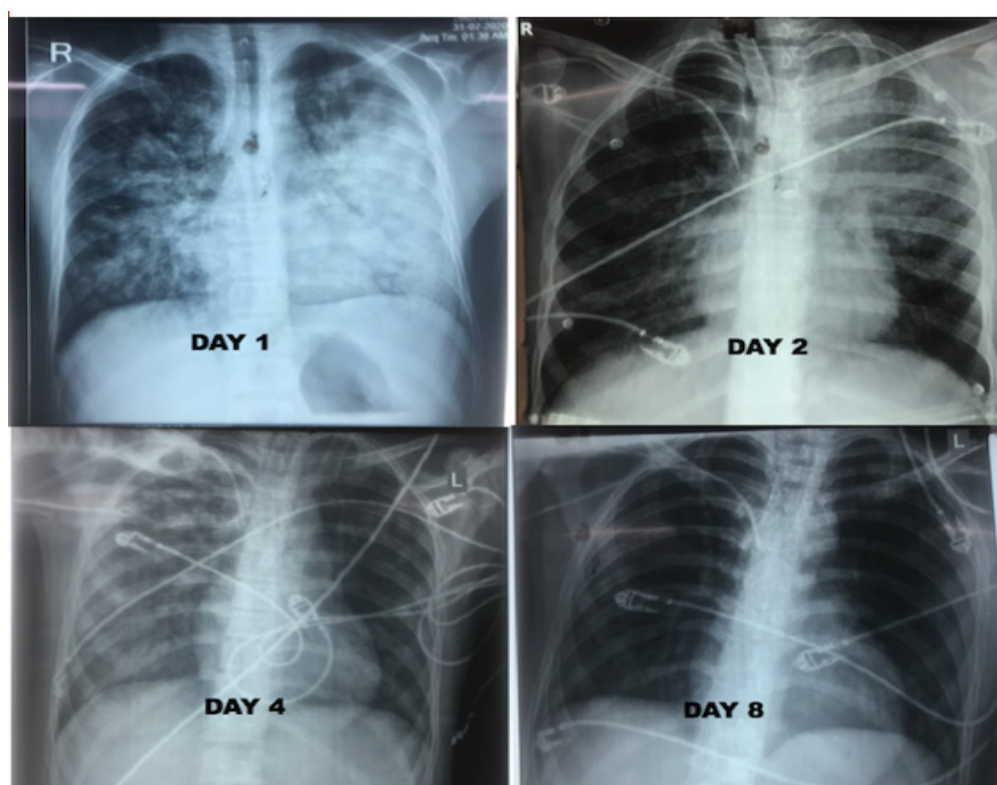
Chest radiograph also showed significant clearing of infiltrates in left mid and lower zones.
